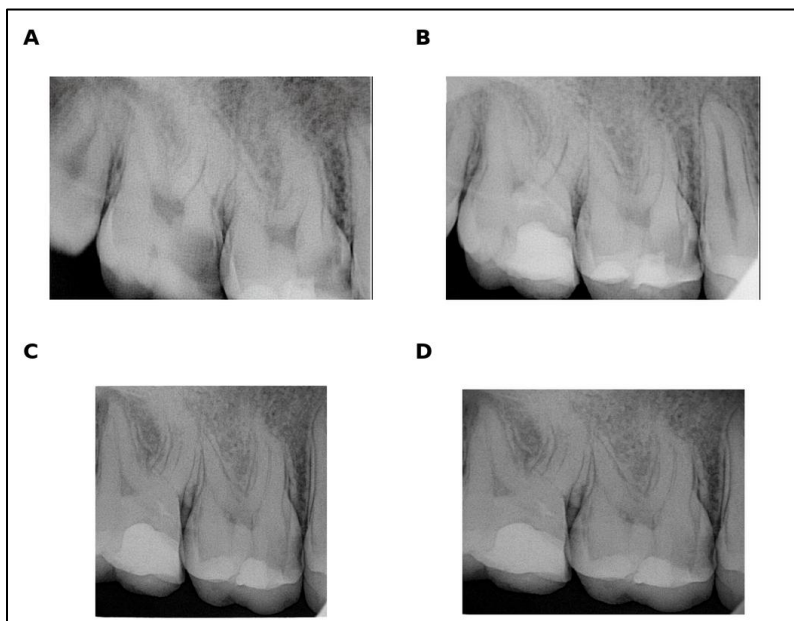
Case 4 radiographic sequence for corrected tooth 37. A: preoperative radiograph; B: immediate postoperative radiograph; C: 6-month follow-up; D: 12-month follow-up.
